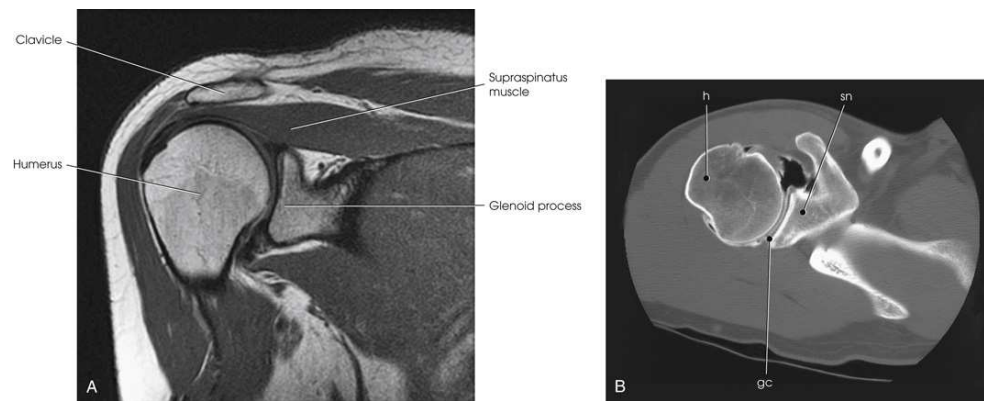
(A) Coronal MRI of shoulder. Note articular cartilage around humeral head and muscles closely surrounding bone. (B) Axial CT of shoulder, midjoint. Note position of bones relative to each other and articular cartilage in glenoid cavity. *gc*, Glenoid cavity; *h*, humerus; *sn*, scapular neck. From Kelley LL, Petersen CM. *Sectional anatomy for imaging professionals*. 2nd ed. St Louis: Mosby; 2007.
